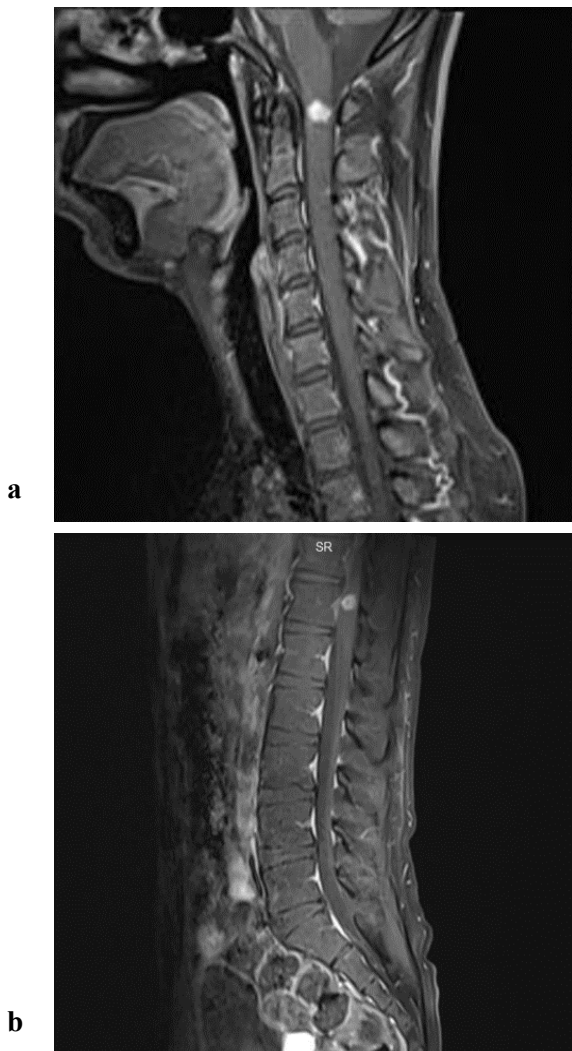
The contrast-enhanced whole spine MRI reveals multiple round lesions with poorly defined or unclear boundaries located within the intramedullary region of the spinal cord, specifically at the C1 vertebral level (a) in the cervical spine and the T12 vertebral level (b) in the thoracic spine
